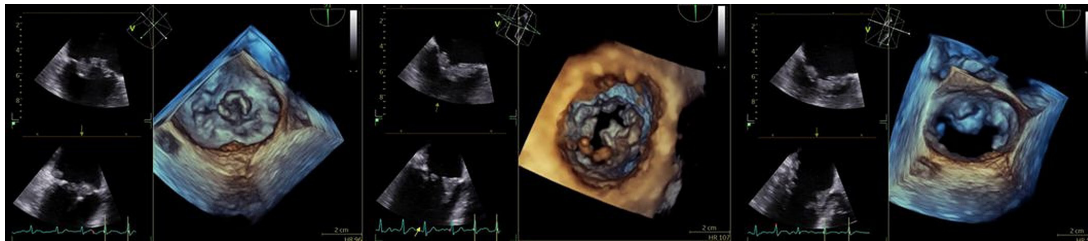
Transoesophageal echocardiogram with two vegetations seen on the mitral valve. On the A2 scallop, the vegetation measures 1.2×0.6 cm. Second vegetation on the A3 scallop is frond-like and measures 1.9×1.1 cm. (Left: two-dimensional representation; right: three-dimensional reproduction.)
